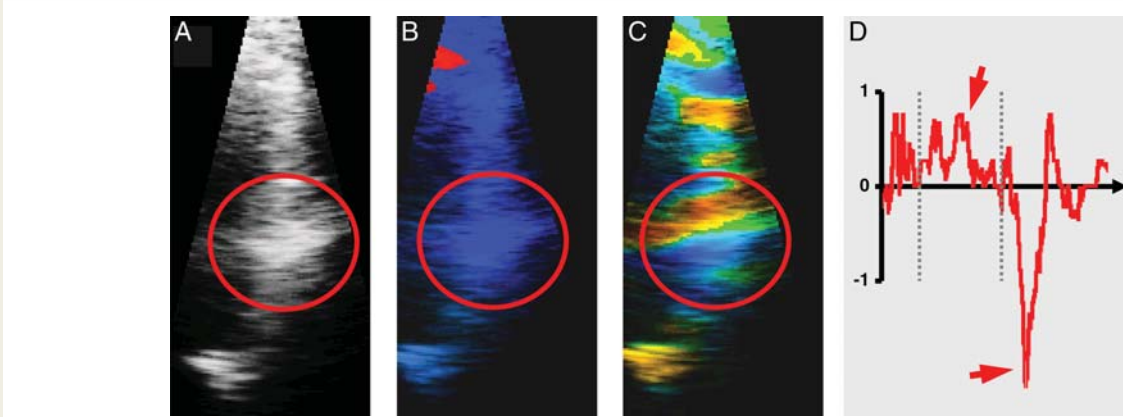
Reverberation artifacts are best recognized in the grayscale image (A) and can be missed in the color Doppler display (B). They become again obvious in the color coded SR display as parallel yellow and blue lines of high intensity (C). If only the reconstructed time curve from such a region is considered (D), artifacts may be mistaken as highly pathologic curves mimicking “systolic lengthening” or “postsystolic shortening” (red arrows). Reproduced with permission from Voigt.¹⁸⁰
